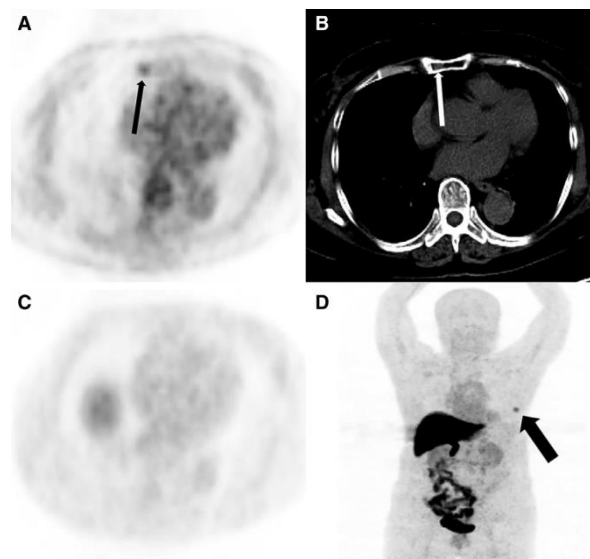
A 71-year-old woman with newly diagnosed estrogen receptor-positive breast cancer. (A): Axial ^{18}F -FDG positron emission tomography (PET) shows right manubrium focal uptake (black thin arrow). (B): Axial computed tomography (CT) show an inhomogeneous density of partial manubrium on one level (white thin arrow). (C and D): ^{18}F -FES PET has no uptake in the manubrium (black thick arrow shows breast mass uptake). The manubrium lesion was a considered to be a hemangioma during a recent follow-up.
